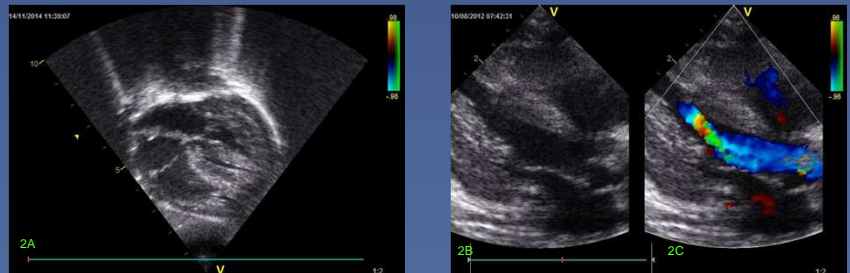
Septal and left ventricular free wall hypertrophy in patient with TMEM70 deficiency in subcostal (2A) and parasternal (2B) views. Color Doppler shows midventricular origin of outflow gradient in left ventricle during systole (2C)
